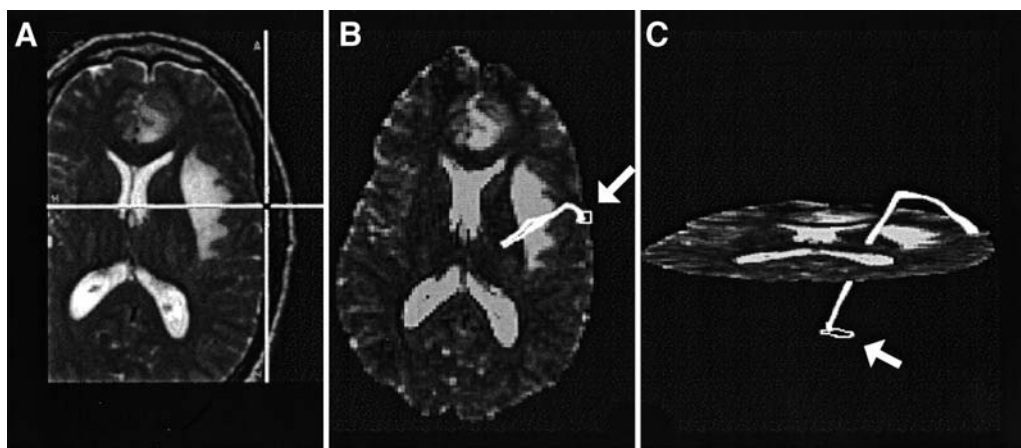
Case 11. Fiber tracking from a stereotactically identified motor site. A: Surgical navigation screen demonstrating a tongue motor site in a patient. The center of the cross-hairs indicates the position of the stereotactic probe tip on T₂-weighted FSE MR images. B: Corresponding axial echo planar image from the DT imaging set revealing the square starting region (arrow) and 3D fiber tracks (white). C: Coronal projection of fiber tracks connecting the cortex with the cerebral peduncle. The outline of the regions drawn in the cerebral peduncle for filtering the fiber tracks is shown (arrow).
